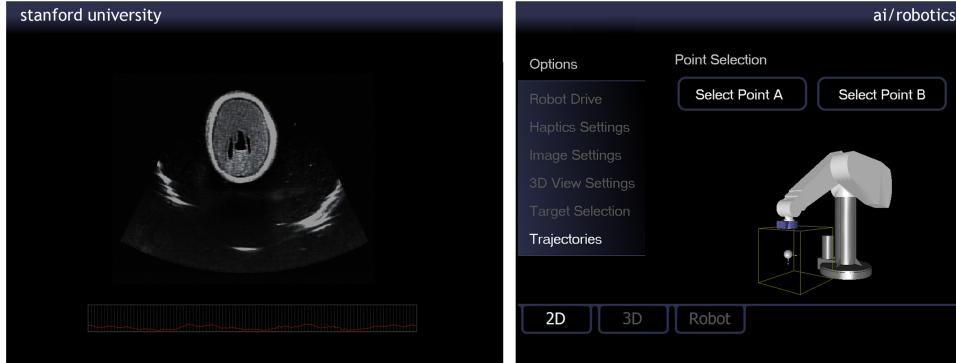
Screenshot of the main interface: (Left) Visualization screen displaying a live 2D ultrasound image. (Right) Command screen which combines all operating modes and user settings of the application.
